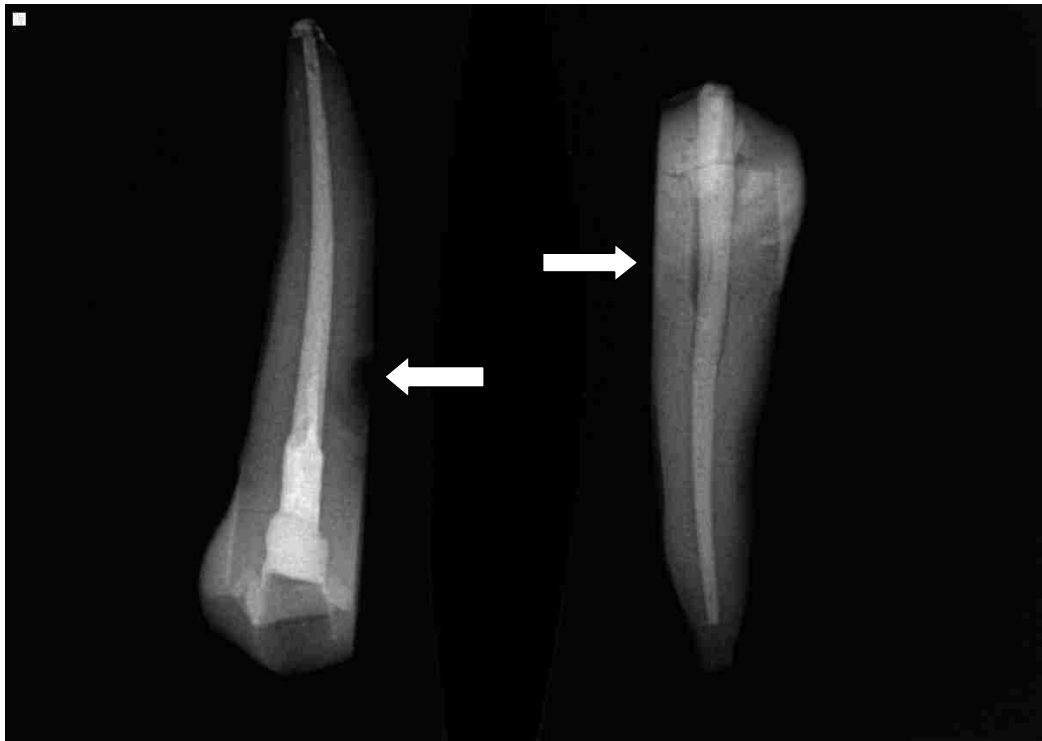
Radiograph of teeth after 40-day microleakage study: GuttaCore sample that displayed turbidity; note root surface defect (left arrow) and gutta-percha positive control that displayed turbidity (right arrow denotes path of leakage).
